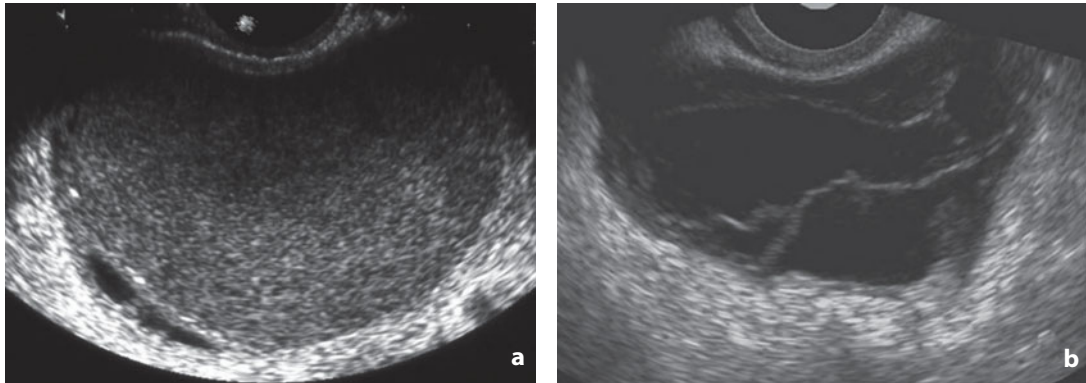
Transvaginal ultrasonography. Endometrioma. a Typical ovarian endometriosis with low-level internal echoes. b Less common appearance of lesion with thick walls and septations. c Rare form of complex mass with solid parietal component (arrow) and thick walls. Peripheral vasculature is identifiable on color Doppler
